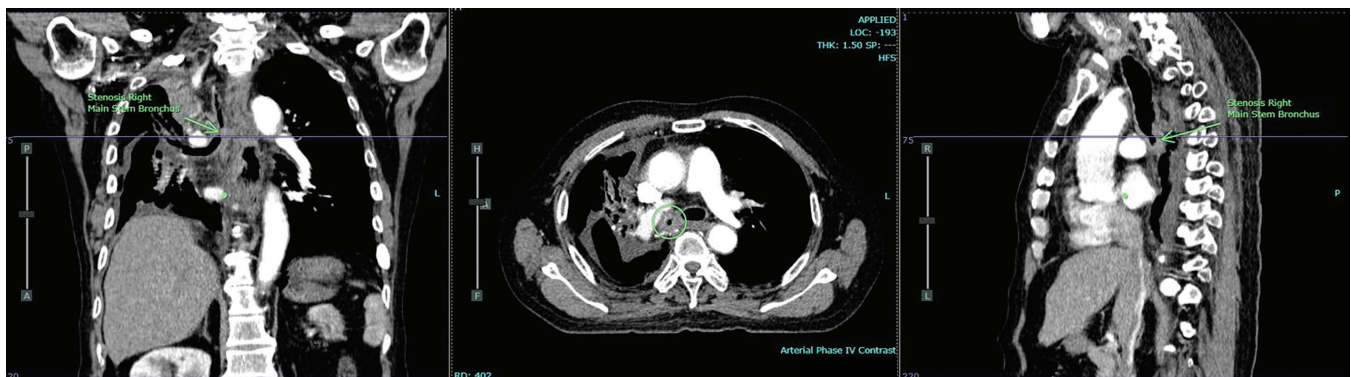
CT scans showing the obstruction of the right main bronchus (green arrow and green circle).
